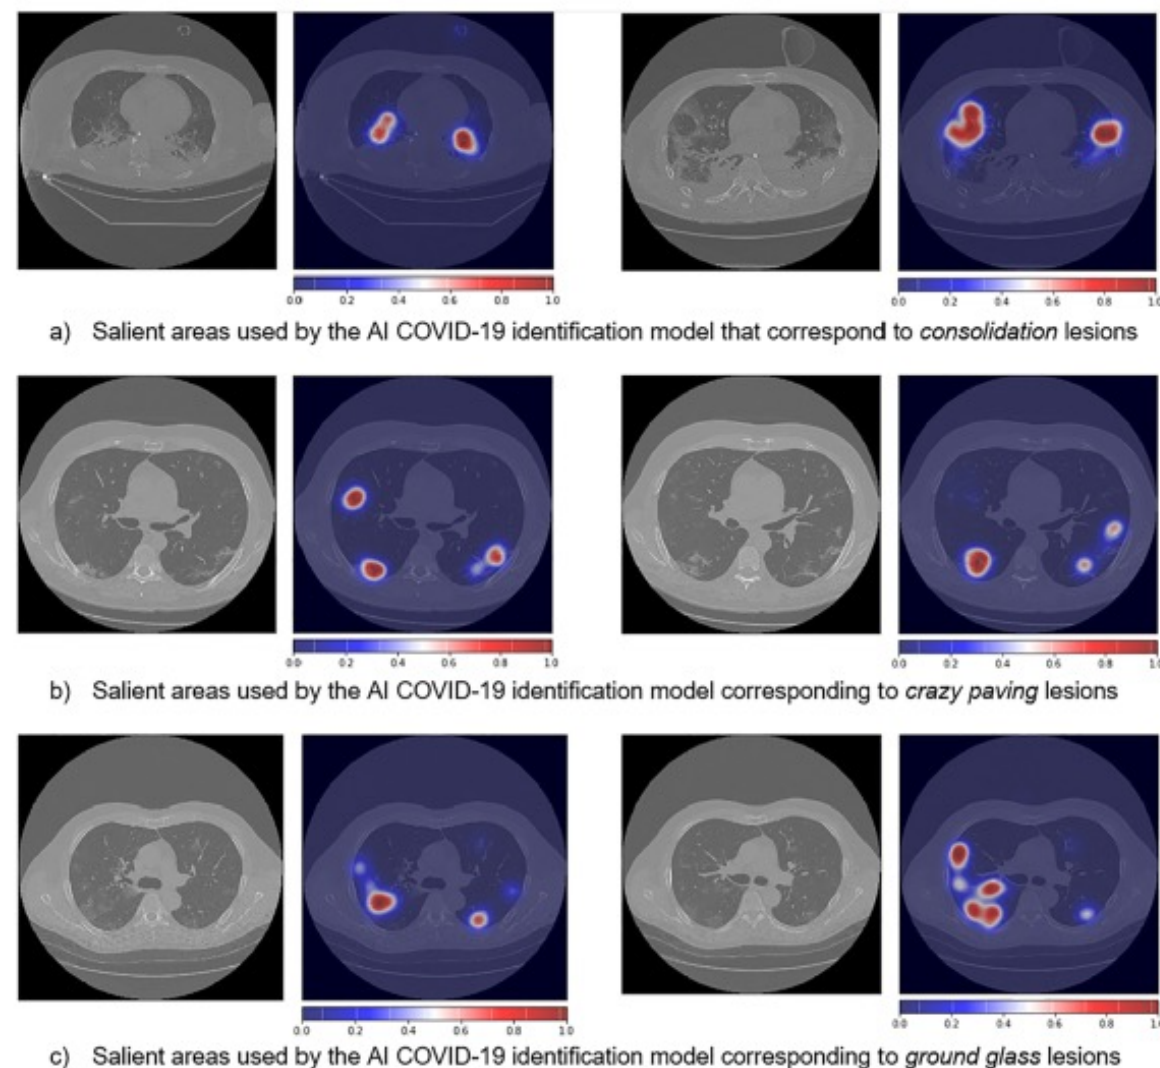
Lung salient areas identified automatically by the AI model for CT COVID-19 identification.
